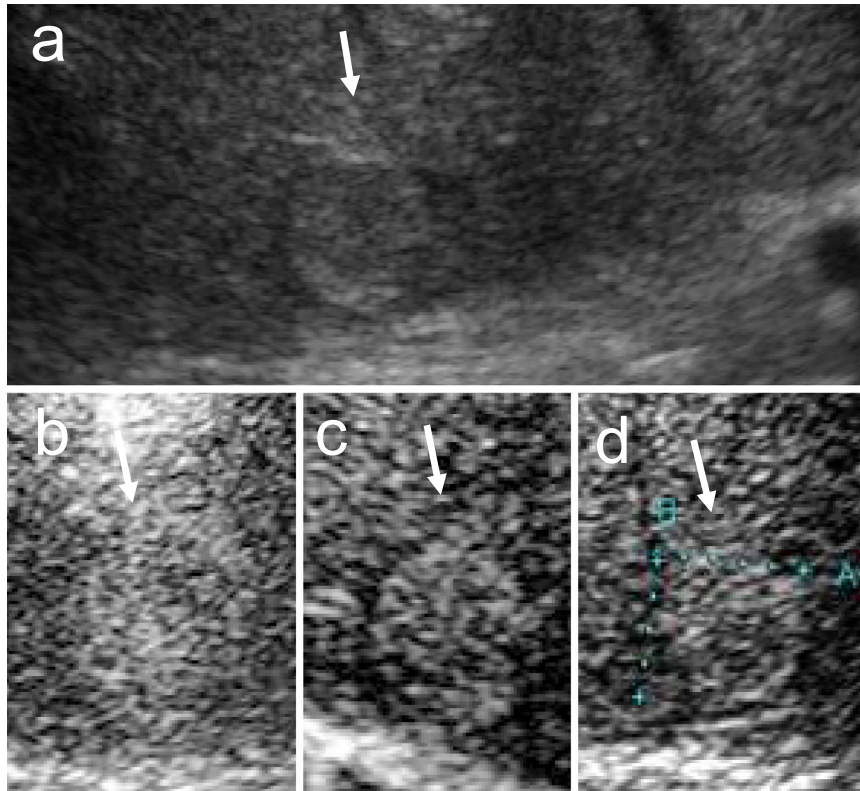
B-mode conventional ultrasonography showed an 18 mm hyperechoic mass in liver segment 2 (S2) (a); and CEUS showed a homogeneously enhanced mass in the arterial dominant phase (b), isoechoic mass relative to the adjacent liver parenchyma during the portal dominant phase (c), and no defects in the postvascular phase (d).
